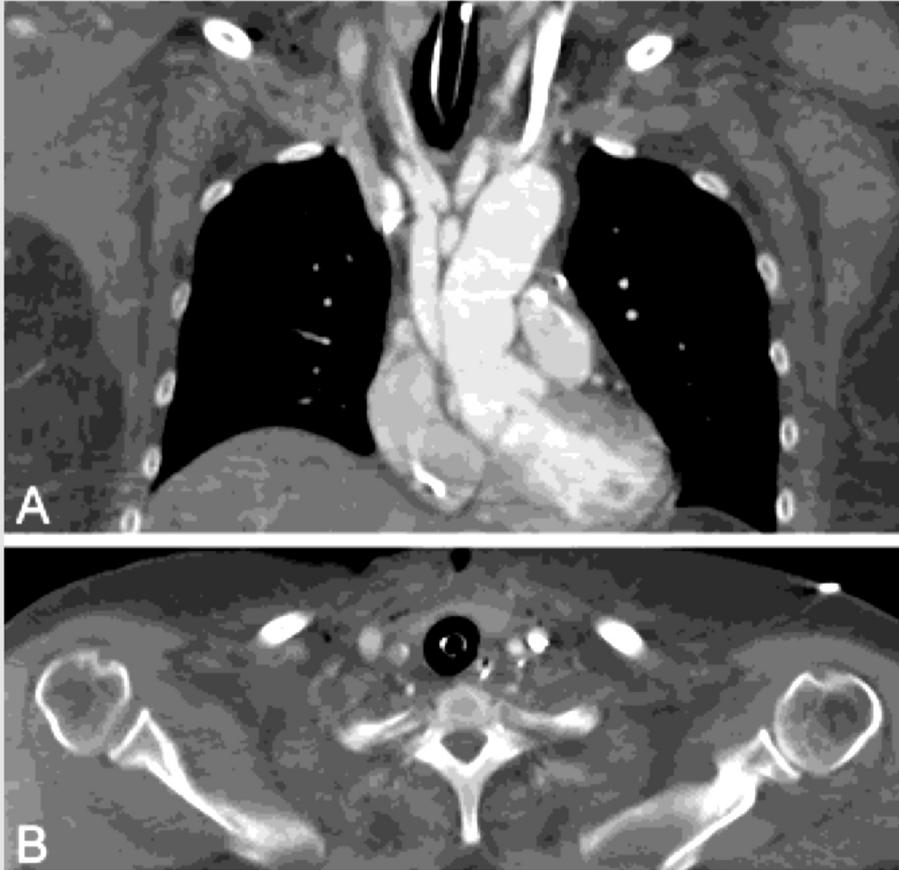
Coronal view of the computed tomography angiography chest demonstrating type A Aortic Dissection with innominate and right common carotid artery involvement. Computed tomography angiogram images showing Type A Aortic Dissection with extension of dissection involving the innominate and right common carotid arteries.
